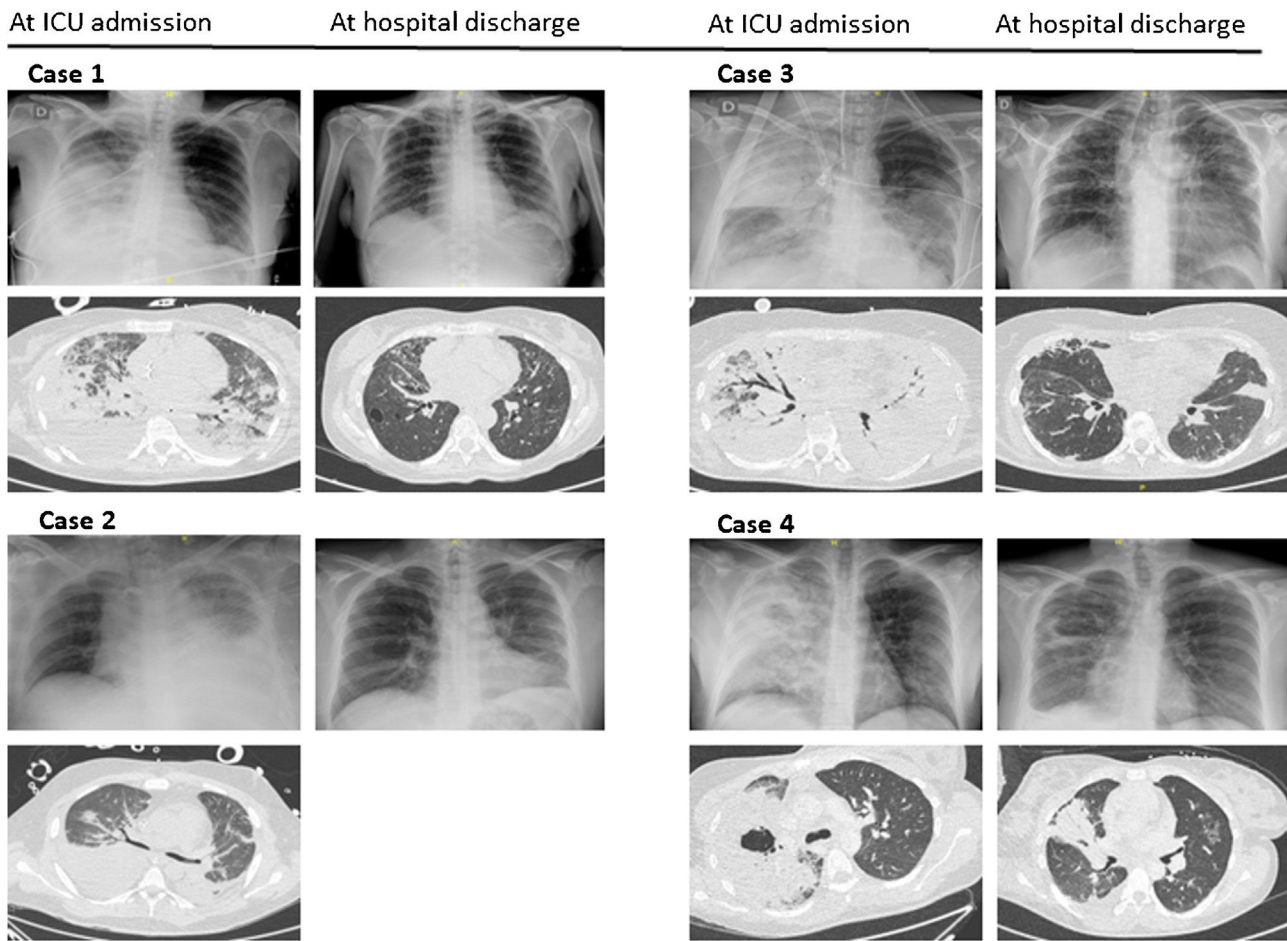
Thorax X-ray and thoracic CT-scan at ICU admission and at hospital discharge.
